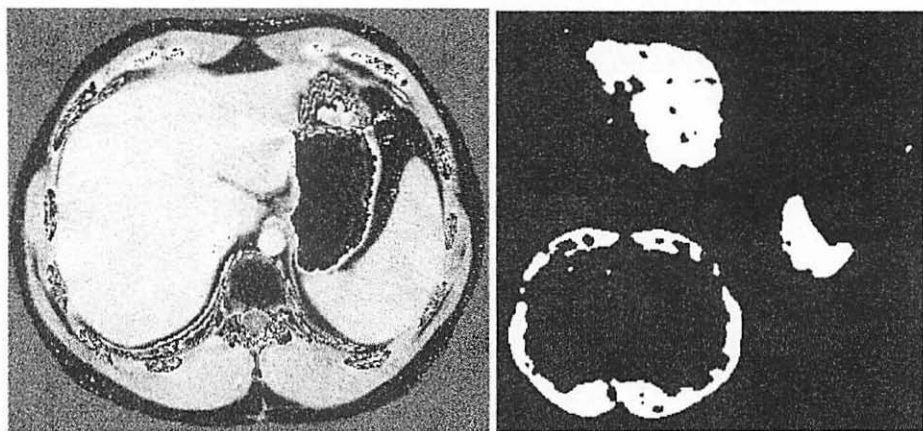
CT slice used for segmentation and segmented organs. (Note that segmented organs were resized and rotated to fit on page.)
